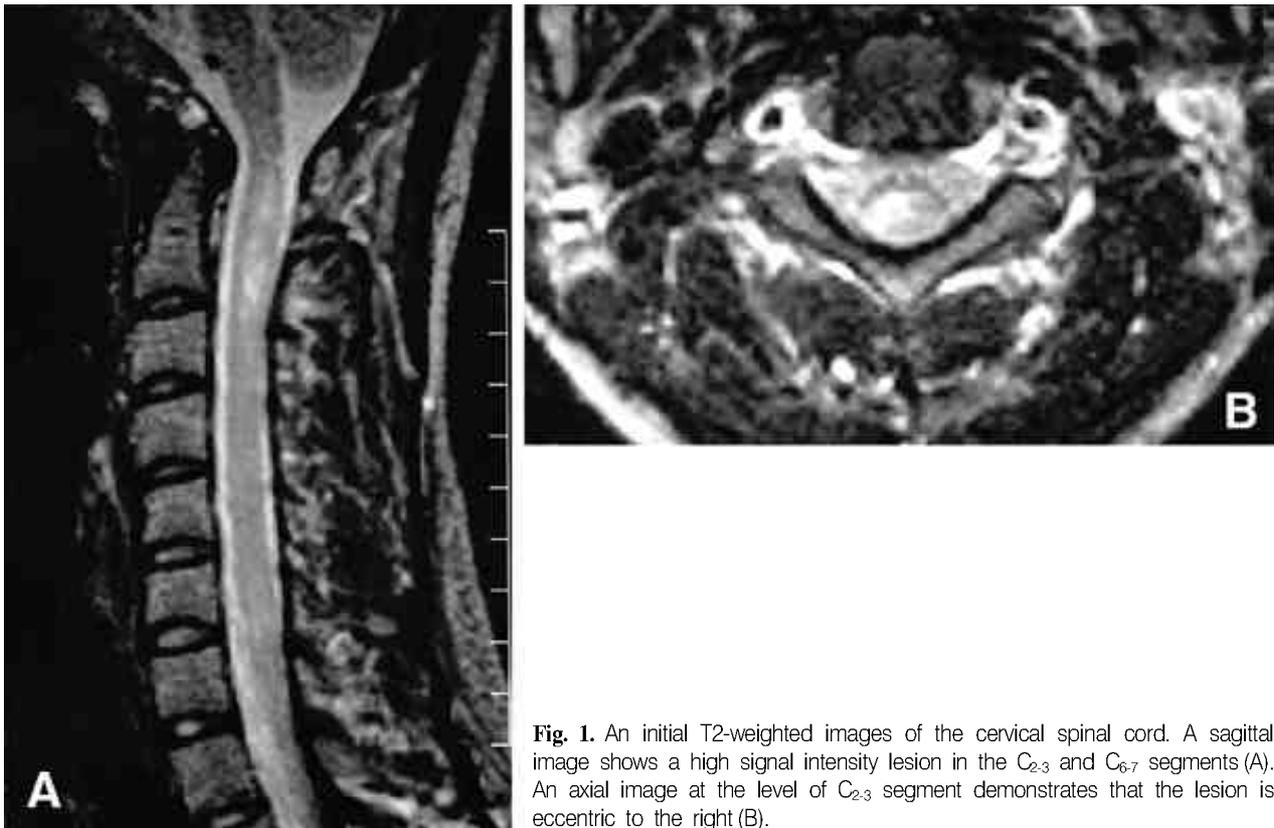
An initial T2-weighted images of the cervical spinal cord. A sagittal image shows a high signal intensity lesion in the C₂₋₃ and C₆₋₇ segments (A). An axial image at the level of C₂₋₃ segment demonstrates that the lesion is eccentric to the right (B).
